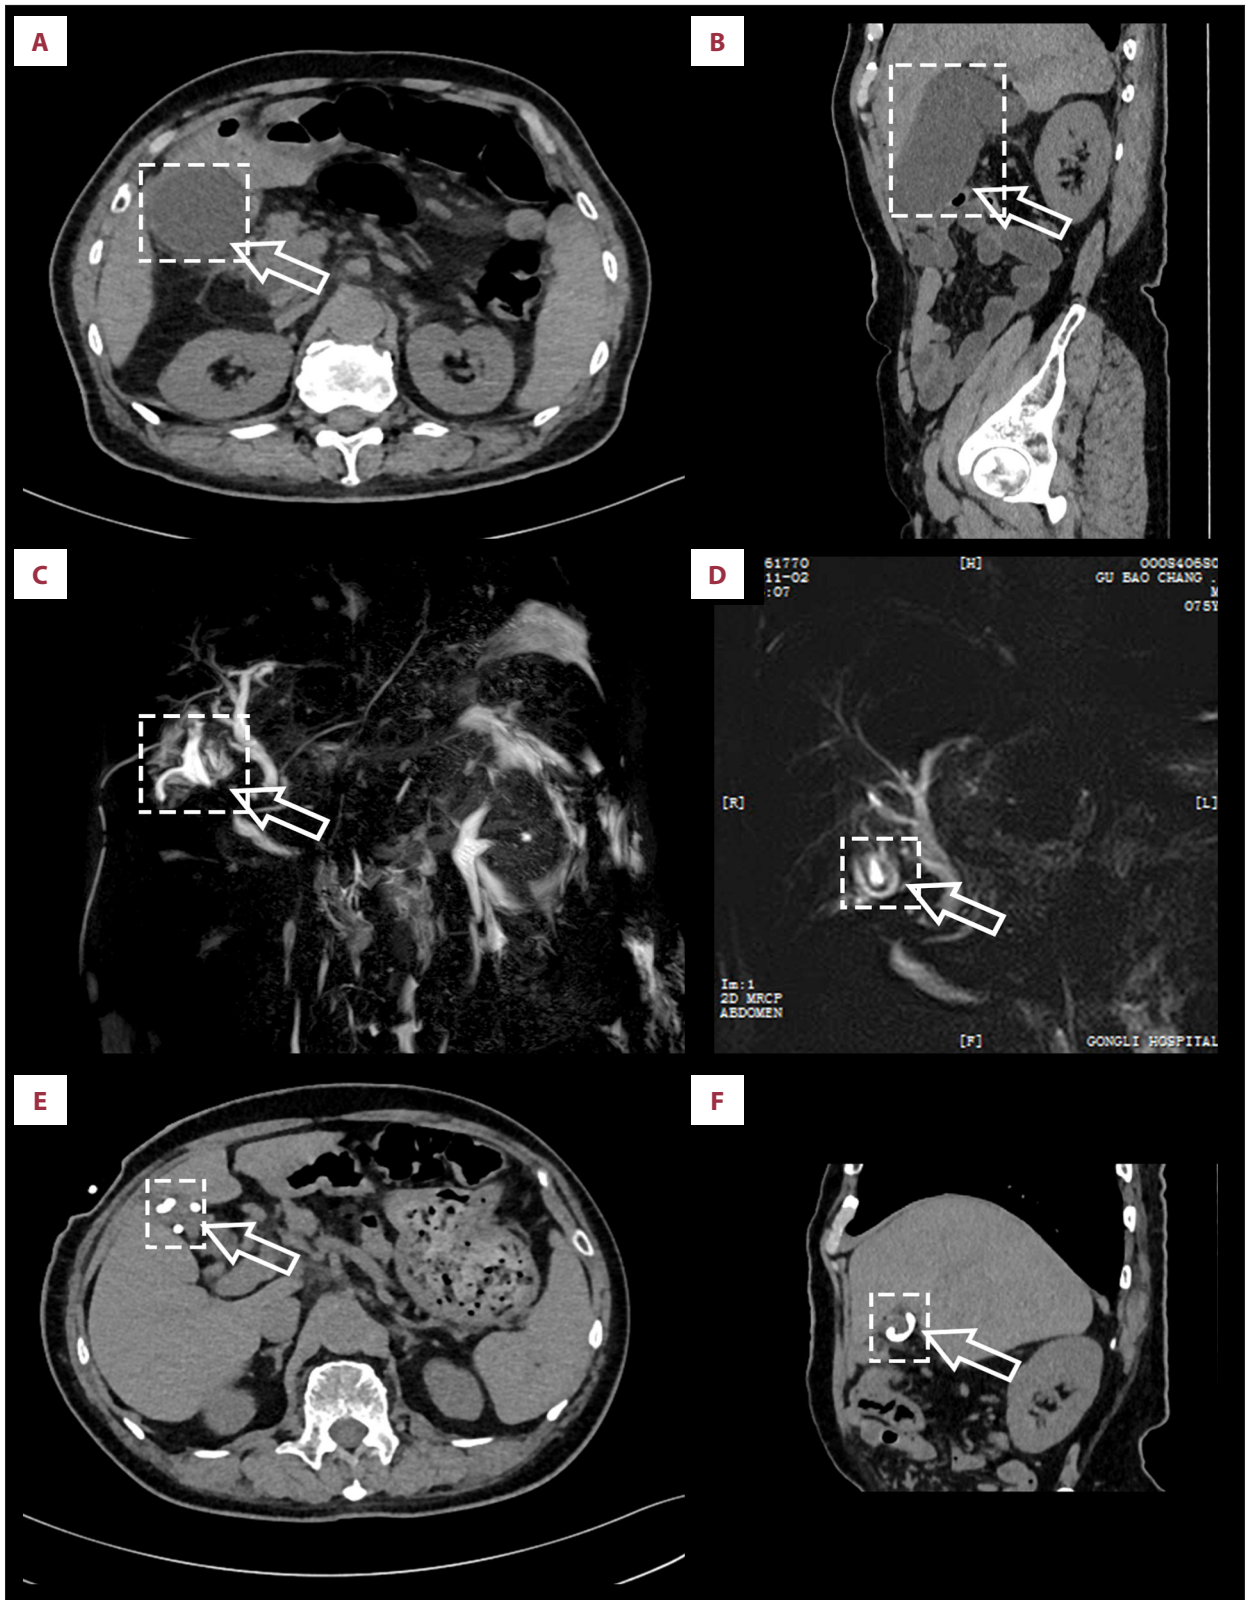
Computed tomography and magnetic resonance images in the treatment course. CT images at the initial diagnosis (A, B), MRI images of the patient who received treatment (C, D), and CT images of the patient at follow-up examination (E, F). White boxes and arrows indicate the size and location of the lesion.
